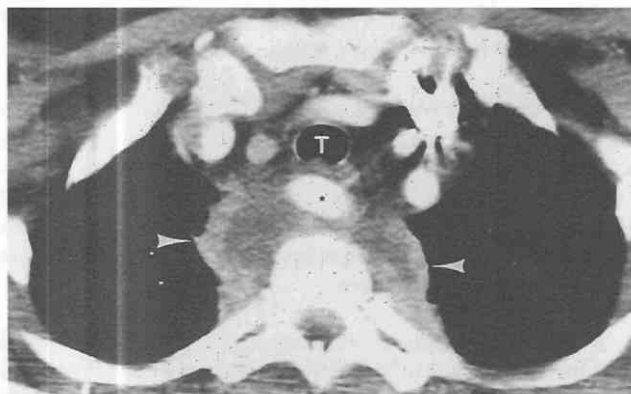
Paraspinal abscess caused by vertebral osteomyelitis. Contrast-enhanced CT shows bilateral heterogeneous low-attenuation paraspinal masses (arrowheads). *Staphylococcus aureus* was cultured from the needle aspirate. An anomalous right subclavian artery (asterisk) is posterior to the trachea (T).
